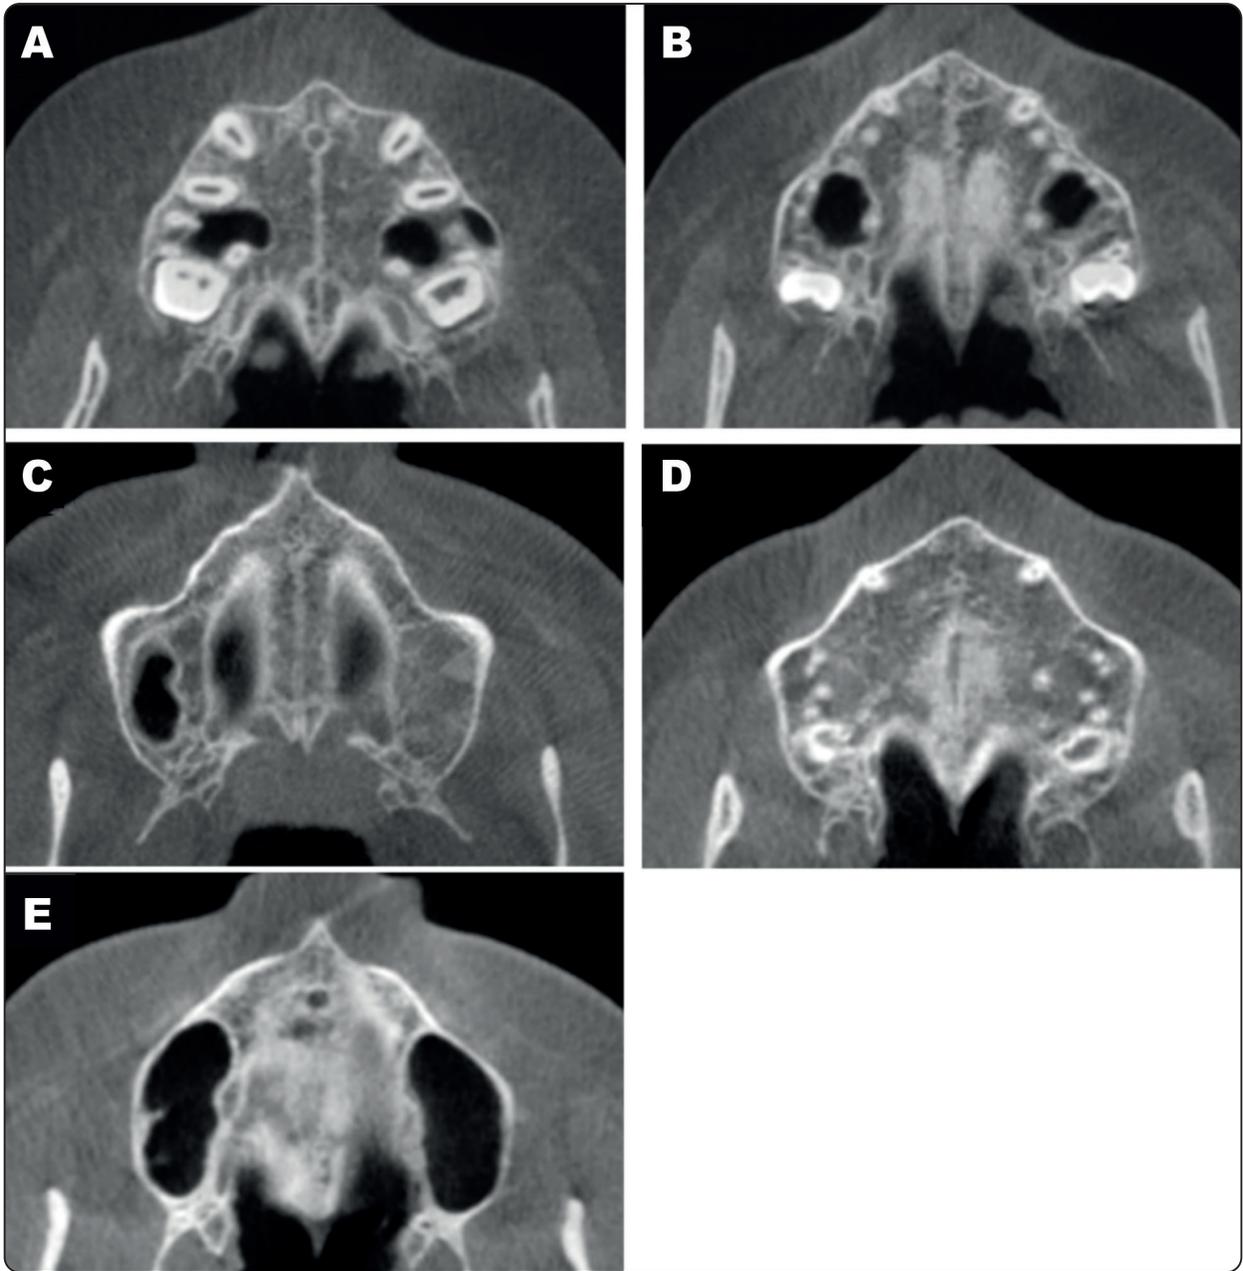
Axial CBCT images revealing MPS maturation stages. (A) Stage A: MPS is nearly a straight high-density sutural line with little or no interdigitation. (B) Stage B: MPS assumes an uneven shape and looks like a scalloped high-density line. (C) Stage C: MPS looks like two parallel, scalloped, high-density lines separated by small low-density spaces in the suture maxillary and palatine regions. (D) Stage D: MPS has been obliterated in the palatine region, with maturation proceeding from posterior to anterior. (E) Stage E: Obliteration of the MPS has occurred in the maxilla. The actual suture is not visible in at least a portion of the maxilla. The bone density at this stage is the same as other palate regions, and the parasutural bone density is increased.
